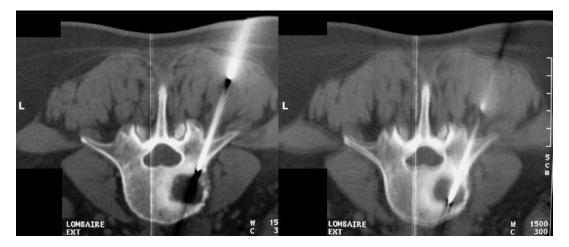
Axial spinal lumbar CT scan when performing CT-guided needle biopsies in the same patient as in Fig. 15.2
